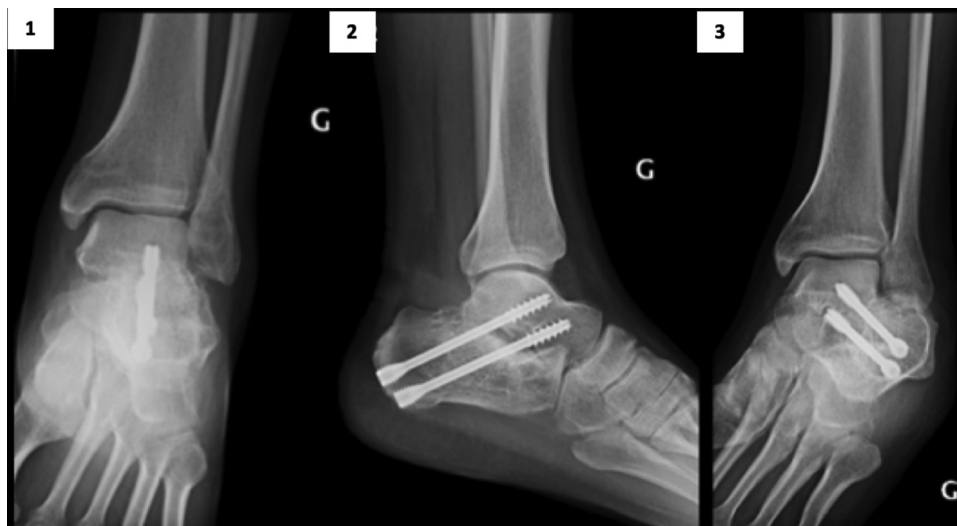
Control radiograph. 1: Antero-posterior ; 2: lateral; 3: broaden incidence. G =left.
